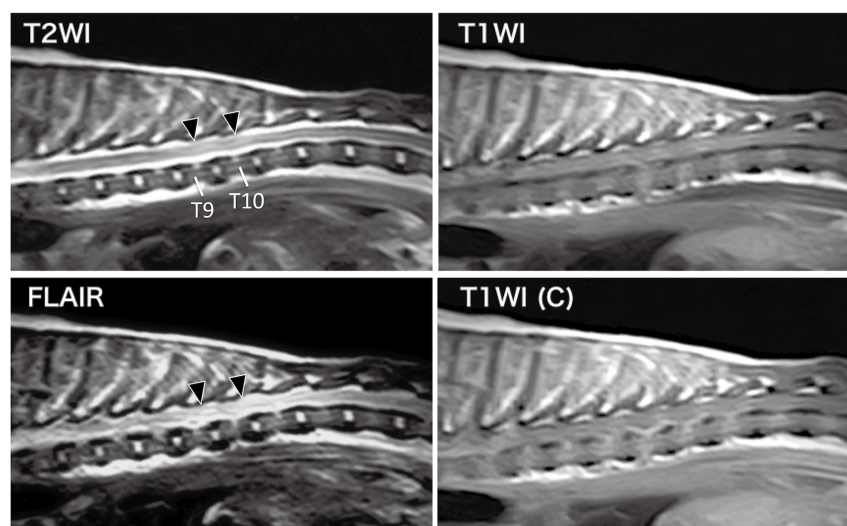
Sagittal magnetic resonance images of the thoracic spinal cord. T2-weighted images (A), T1-weighted pre-contrast images (B), Fluid-attenuated inversion recovery images (C), T1-weighted post-contrast images (D). The T9–10 spinal cord segment showed slightly high signal intensity on T2WI and Fluid-attenuated inversion recovery images (black arrowheads).
